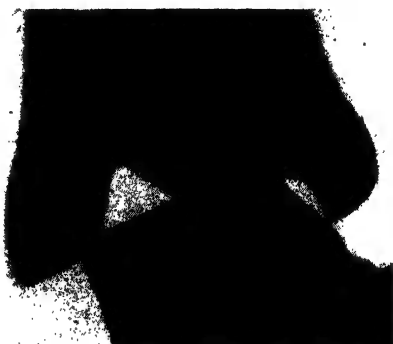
Severe sprain of the ankle. Rupture of the fibular collateral ligament without fracture. The dislocation of the talus is only seen if the ankle is X-rayed in strong inversion. The severity of the injury would consequently not be appreciated in the usual X-ray.
